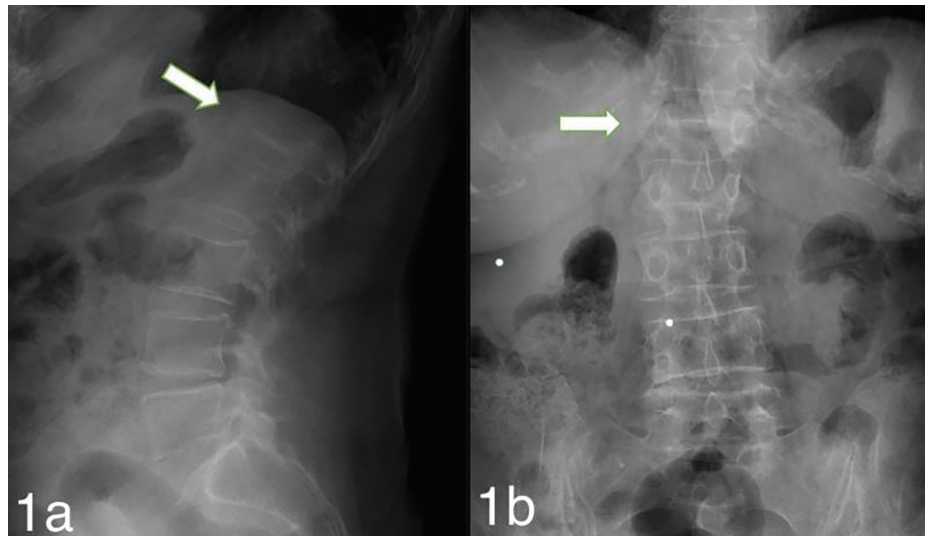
a) Preoperative lateral X-ray, b) Preoperative anteroposterior X-ray.
